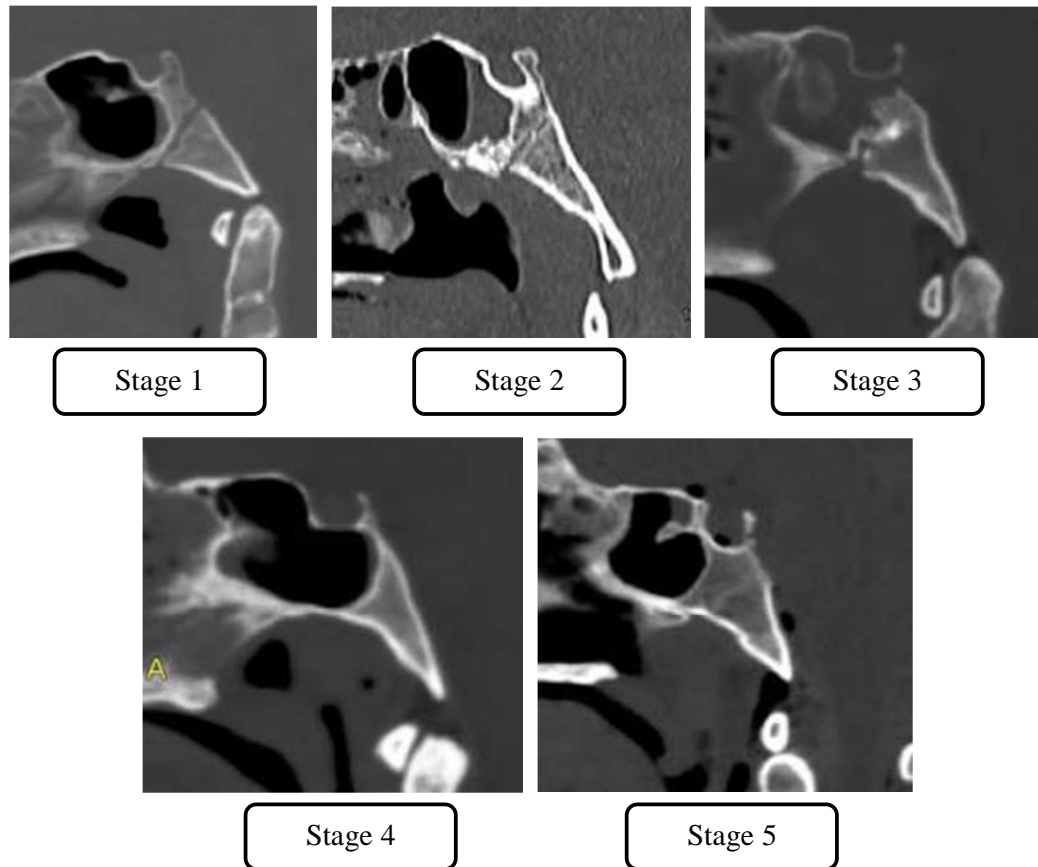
Radiographic assessment of Speno-occipital synchondrosis showing 5 stages of fusion.
